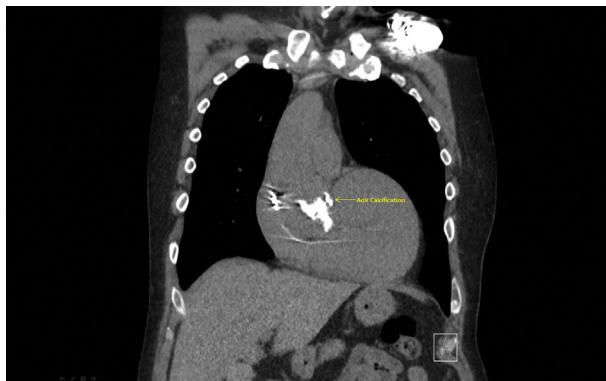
Pre-SAVR CT image showing aortic valve (AoV) calcifications.
